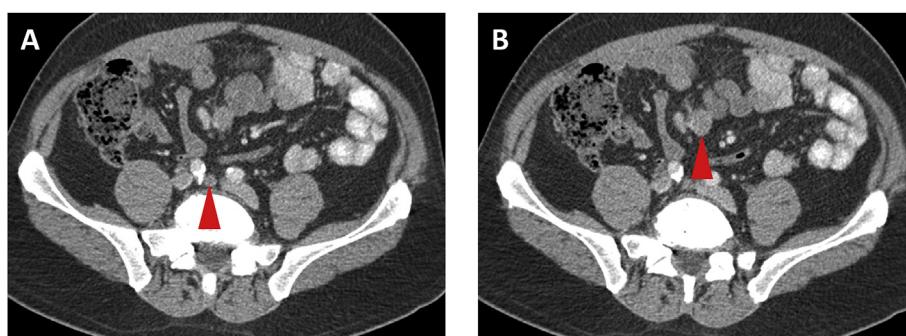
(A) Follow-up, post-chemotherapy axial contrast-enhanced CT image showing treatment response in the lymph node inferior to the aortic bifurcation, with short axis measurement now 0.8 cm (arrowhead). (B) However, the mesenteric adenopathy remained unchanged after chemotherapy on the follow-up contrast-enhanced CT (arrowhead).
